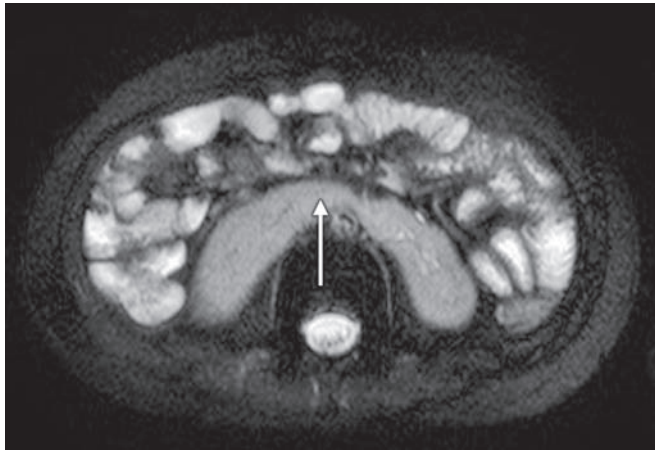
Horseshoe kidney on abdominal MR scan. Axial T2-weighted (fat saturated) image demonstrates fusion of the lower poles of the kidneys anterior to the spine (arrows)
